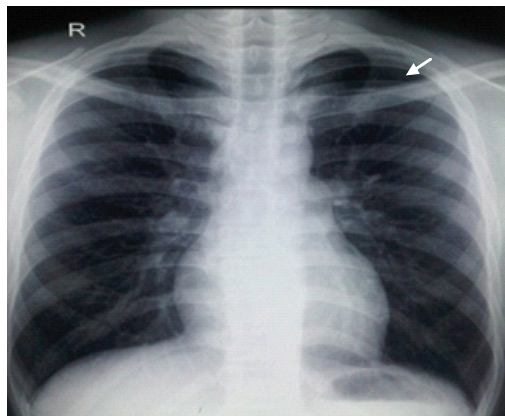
Fourth chest X-ray (arrow pointing pleural line)
